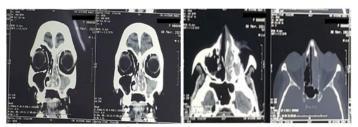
coronal CT- scan: left pansinusitis and right sphenoidal and ethmoidal sinusitis of chronic appearance, left pre-septal cellulitis associated with ipsilateral dacryocystitis.
